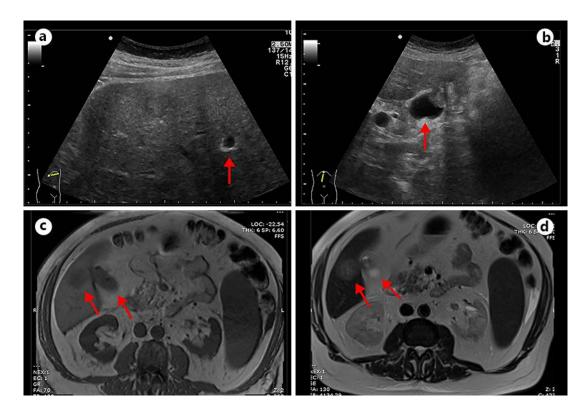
Radiological findings. a Ultrasound: bulls-eye aspect of the liver lesion (red arrow). b Ultrasound: mass in the wall of the gallbladder (red arrow). c T1-weighted MRI: low signal of the liver lesion (left red arrow) and gallbladder mass (right red arrow). d T2-weighted MRI: high signal of the liver lesion (left red arrow) and a partly high, partly low signal of the gallbladder mass (right red arrow).
